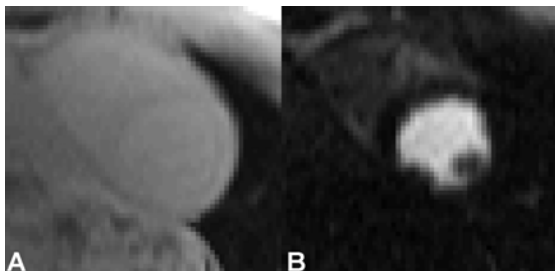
Representative PD (left) and T1-weighted (right) images.
